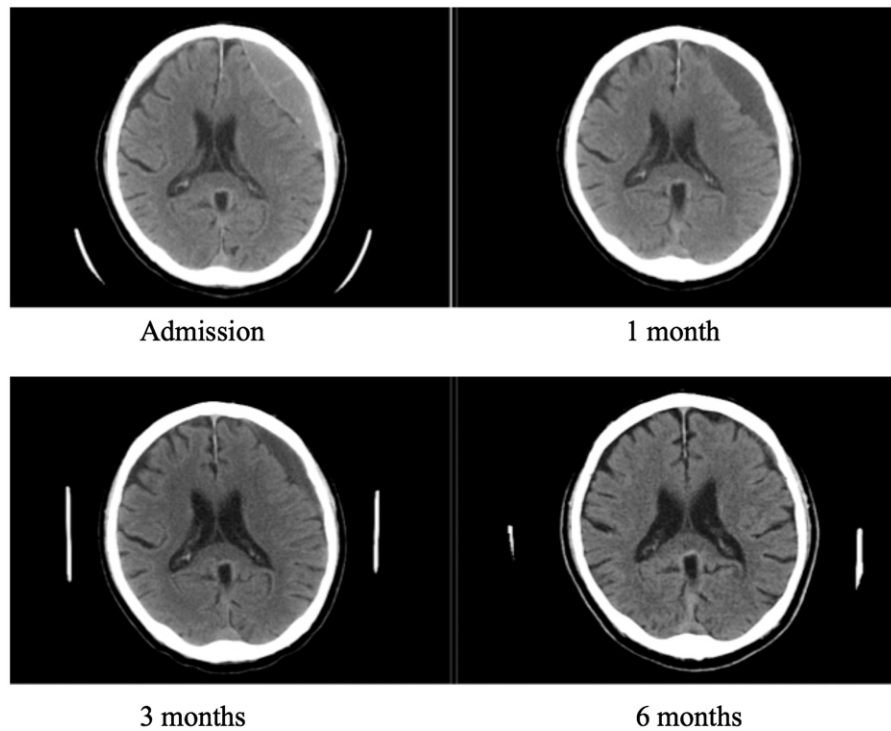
CT brain scan of a 81-year-old gentleman presented with confusion.
